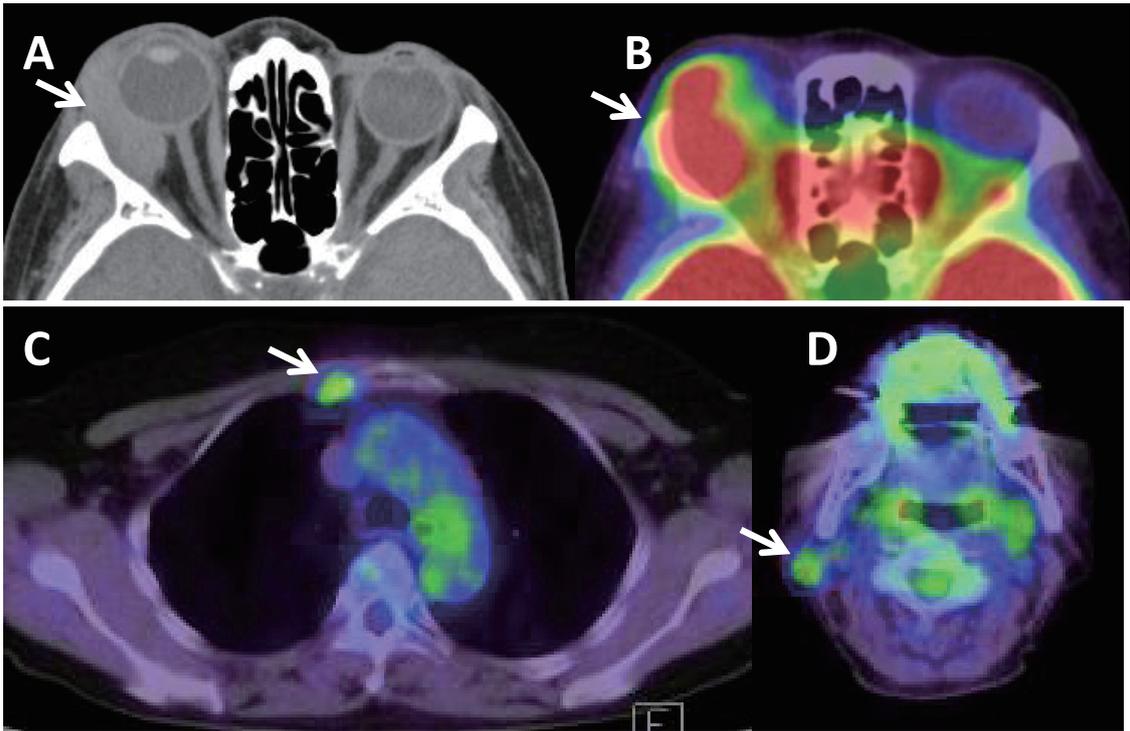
Magnetic resonance imaging (*A*) and 2- ^{18}F fluoro-2-deoxy-D-glucose positron emission tomography fused with computed tomography (FDG-PET/CT) (*B*) of the orbital lesion (maximum standardized uptake value: SUVmax = 13.10) on the right side in 2012. Note also abnormal uptake sites in parasternal lymph node (SUVmax = 4.24, *C*) and cervical lymph node (SUVmax = 4.31, *D*) on the right side, revealed by FDG-PET/CT.
